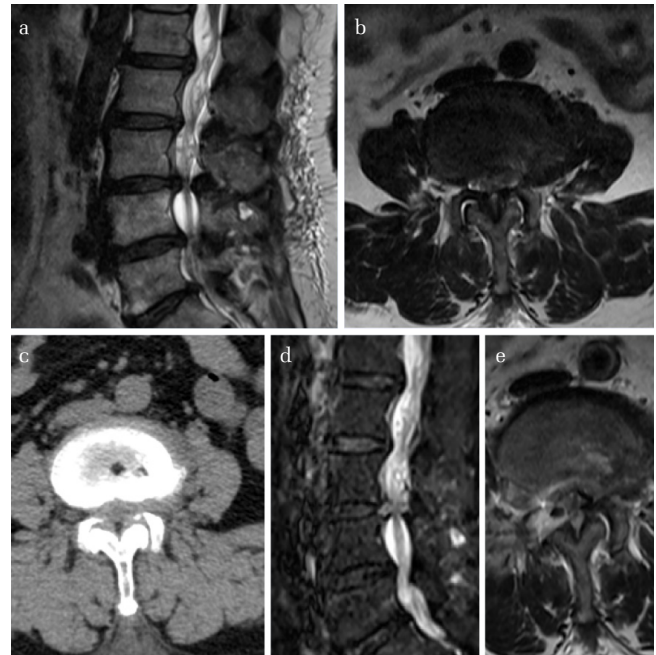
a-e. a. Sagittal T2 magnetic resonance imaging showing lateral recess stenosis of L3-S1 due to ligamentum flavum hypertrophy and disk degeneration. b. Axial T2 magnetic resonance imaging showing lateral foraminal stenosis and nerve compression prior to surgery, at the L3/4 segment (transforaminal approach). There is high intensity fluid in both hypertrophied facet joints indicative of joint inflammation. c. Scans showing severe lateral foraminal stenosis caused by hypertrophy of facet and disk degeneration. d. Postoperative sagittal T2-weighted MRI demonstrating the absence of the hypertrophied ligamentum flavum and herniated disc, as compared with the preoperative MRI view. The diameter of the intraspinal canal has been clearly widened (transforaminal approach). e. Postoperative axial MRI results indicating complete decompression of the right lateral recess and an enlarged spinal canal volume (transforaminal approach)
